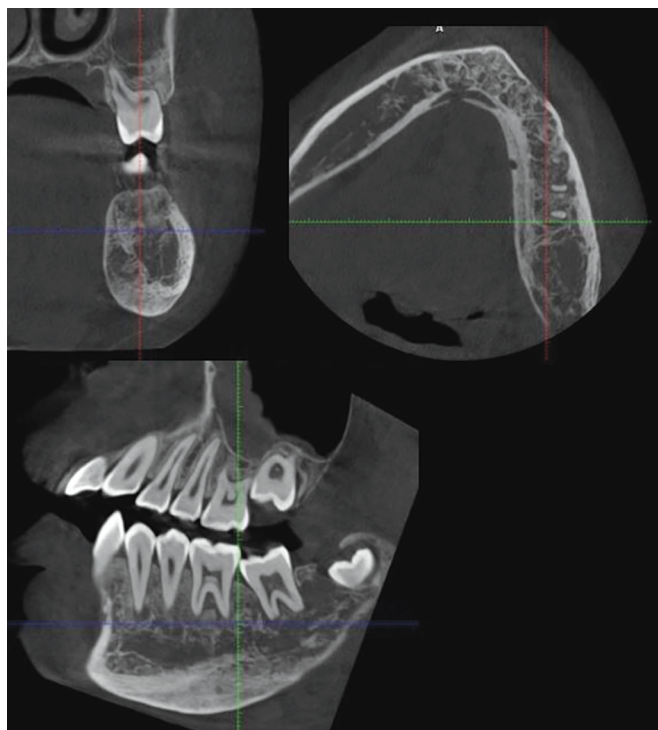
End of treatment CBCT scan
